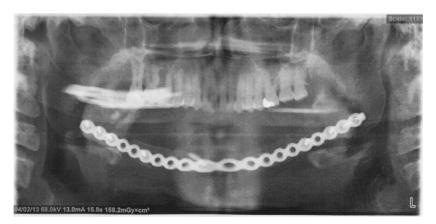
Post-operative radiograph of the patient after 7 months disclosed absence of lesion.
